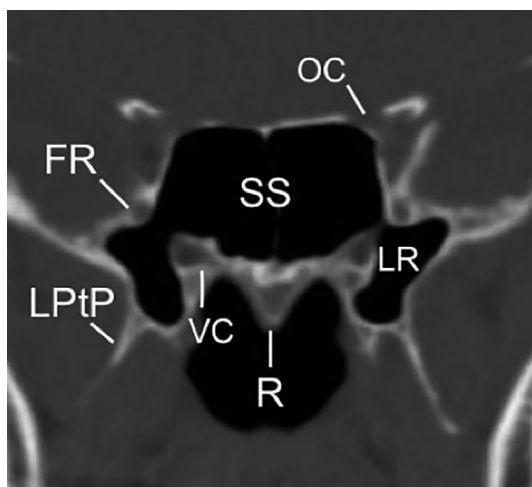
Coronal computed tomography (CT) scan at which the vidian canal and foramen rotundum are visualized. FR, foramen rotundum; LR, lateral recess of sphenoid; LPTP, lateral pterygoid plate; OC, optic canal; R, rostrum; SS, sphenoid sinus; VC, vidian canal
